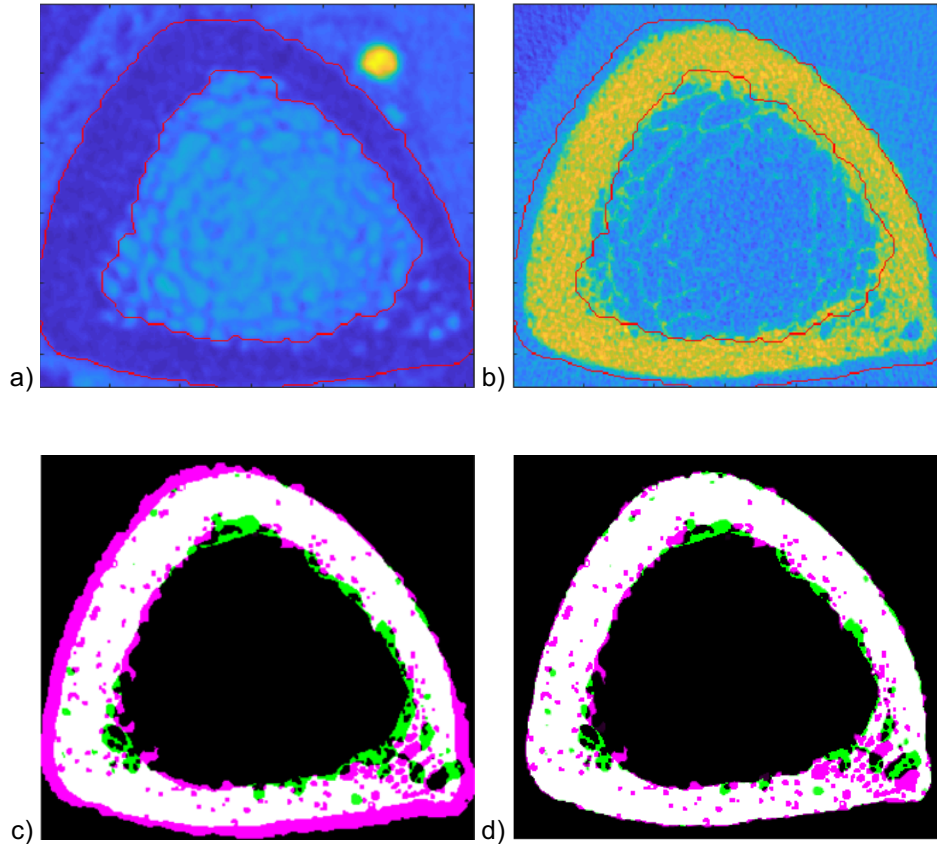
Image comparison of a) MRI, b) CT with MRI bone boundary highlighted, c) overlay of bone + pore masks from MRI and CT before non-rigid registration, and d) overlay of bone + pore masks from MRI and CT after non-rigid registration
